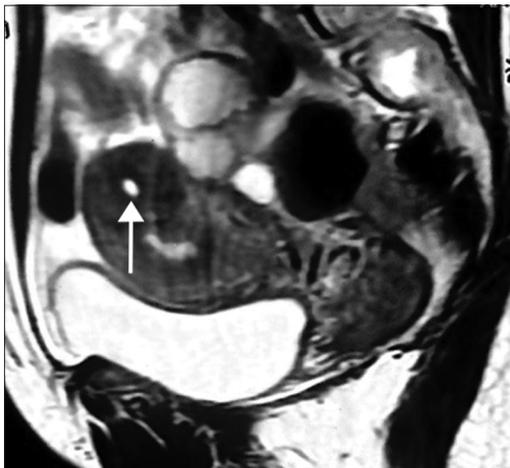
CT abdomen and pelvis. CT Abdomen and Pelvis shows uterus with embedded CuT at fundus (white arrow)
